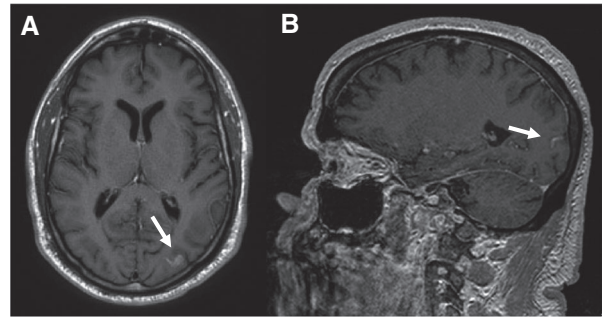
Leptomeningeal metastasis. Postgadolinium T1-weighted (A) axial and (B) sagittal magnetic resonance imaging sequences demonstrate sulcal enhancement in the left occipital lobe suggestive of leptomeningeal metastasis (arrow).
